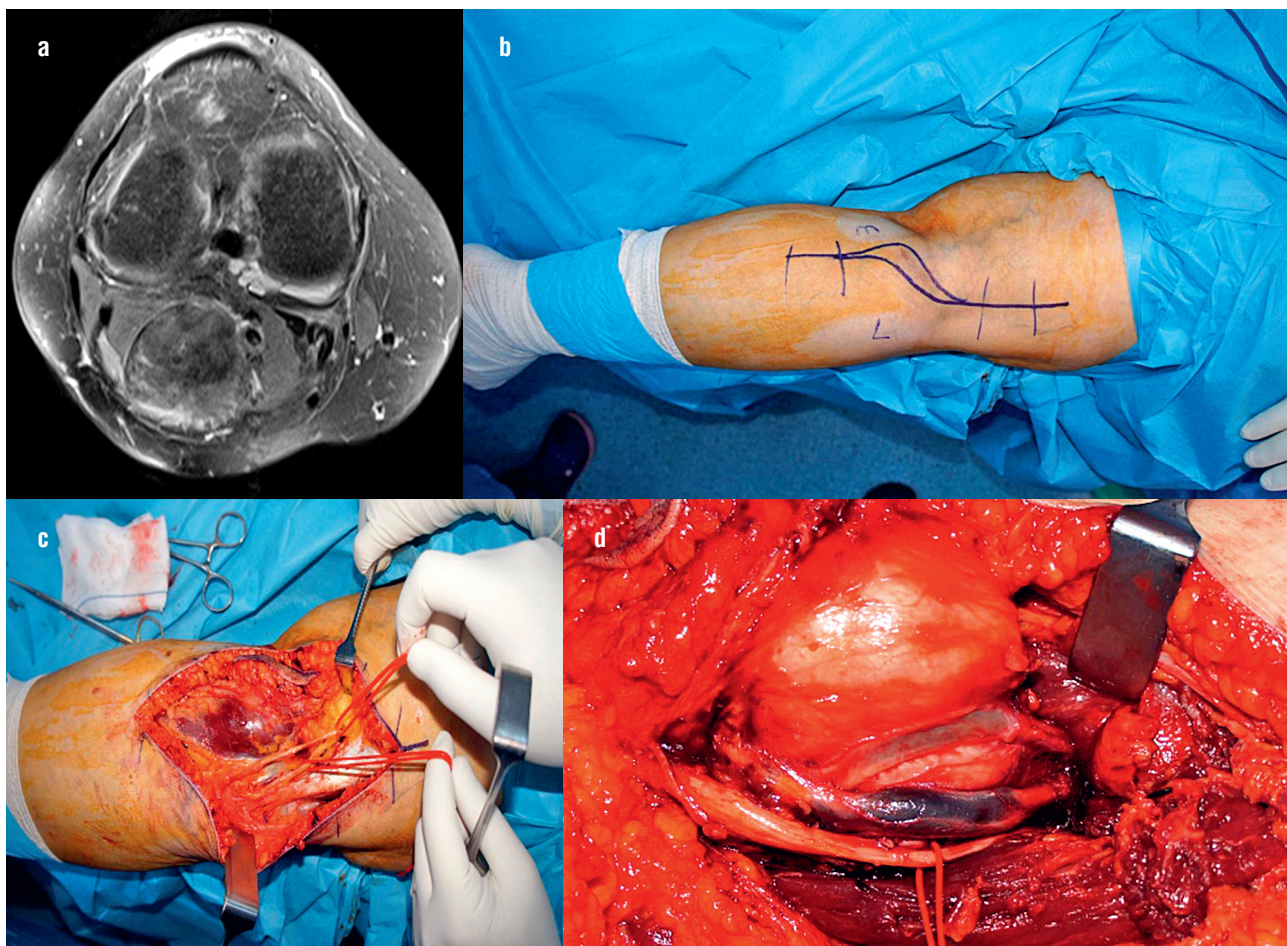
Axial MRI of a popliteal tumor (a). Skin incision that included the biopsy tract (b). Neurovascular stripping from the tumor (c). Tumor and neurovascular bundle proximity (d).
